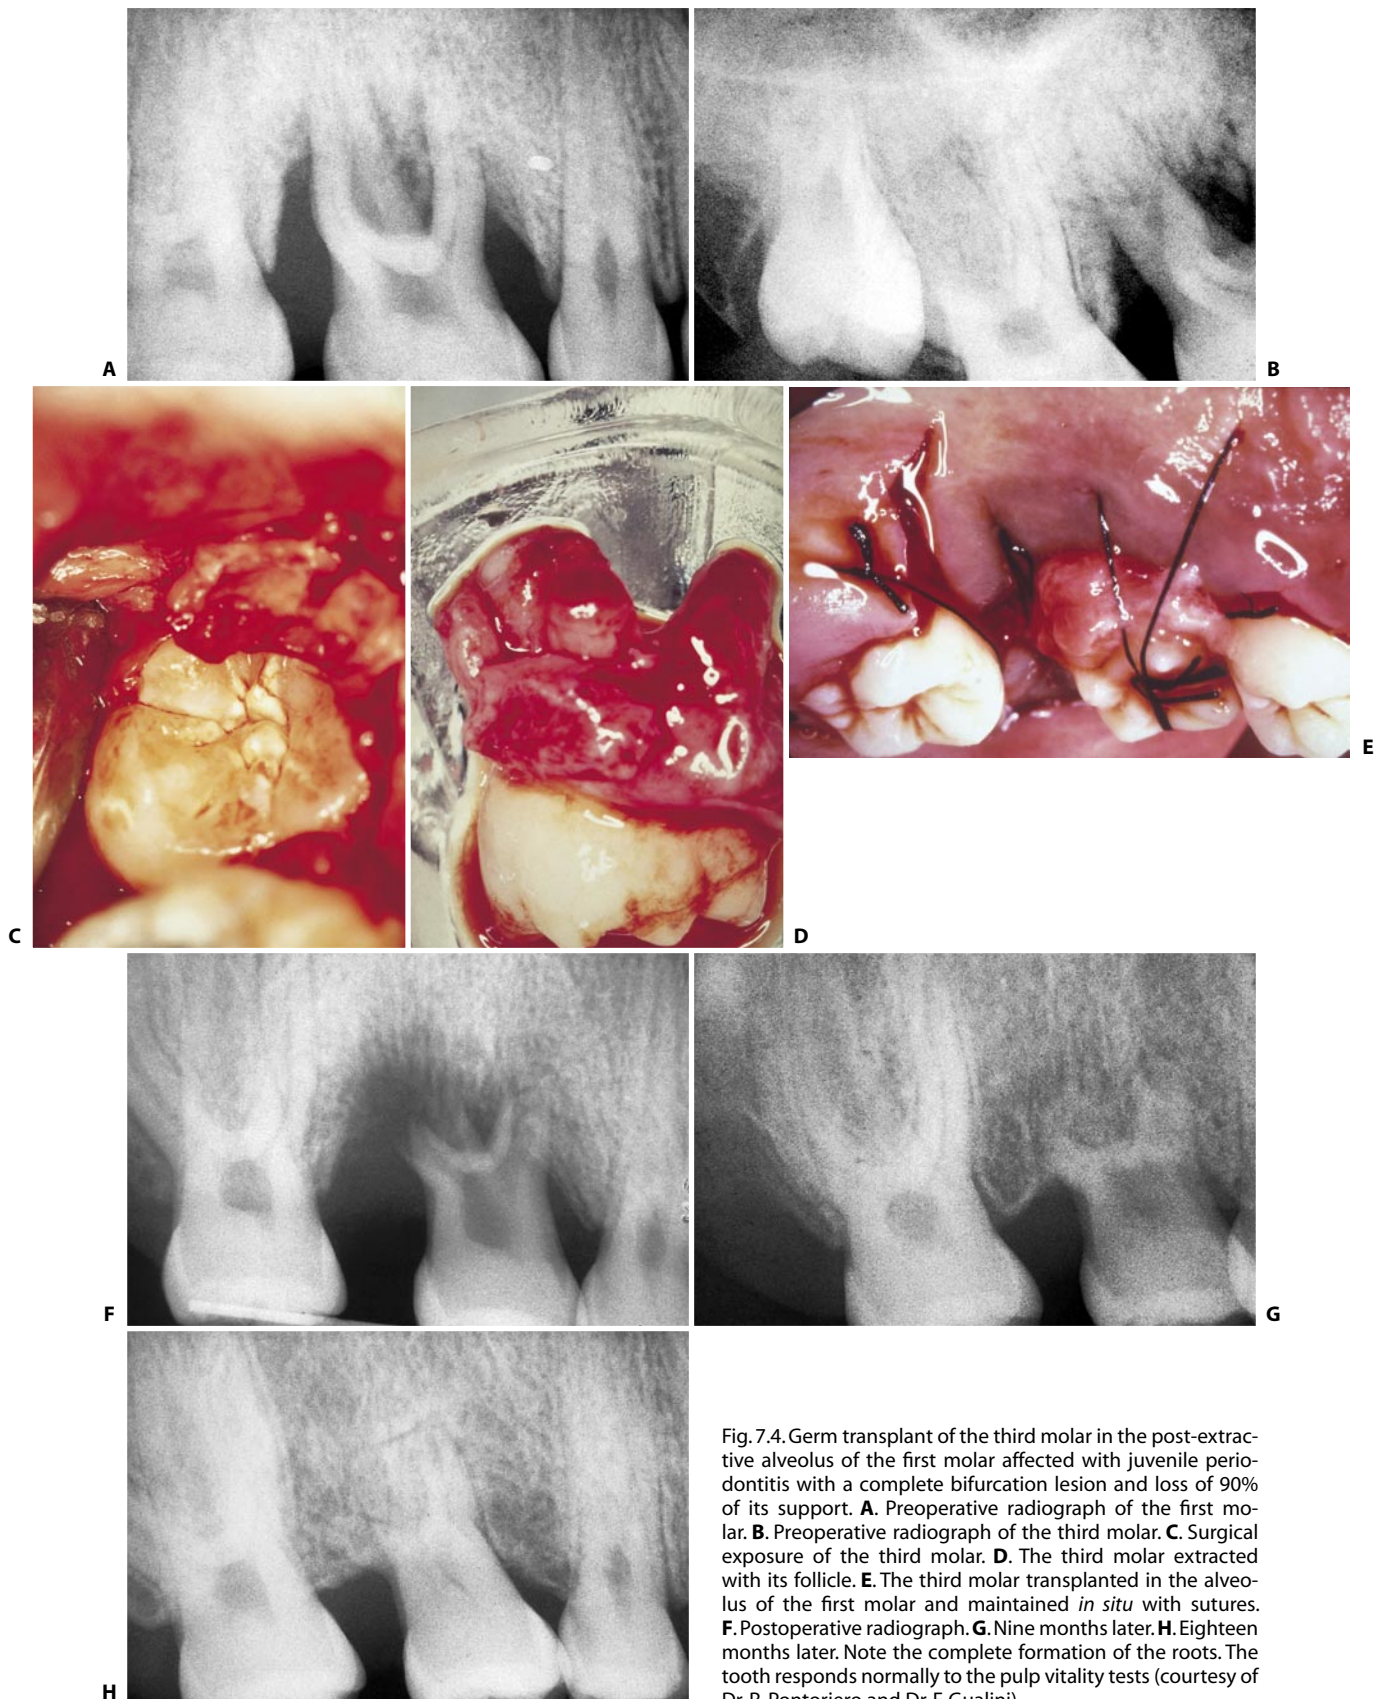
Germ transplant of the third molar in the post-extractive alveolus of the first molar affected with juvenile periodontitis with a complete bifurcation lesion and loss of 90% of its support. A. Preoperative radiograph of the first molar. B. Preoperative radiograph of the third molar. C. Surgical exposure of the third molar. D. The third molar extracted with its follicle. E. The third molar transplanted in the alveolus of the first molar and maintained *in situ* with sutures. F. Postoperative radiograph. G. Nine months later. H. Eighteen months later. Note the complete formation of the roots. The tooth responds normally to the pulp vitality tests (courtesy of Dr. R. Pontoriero and Dr. F. Gualini).
